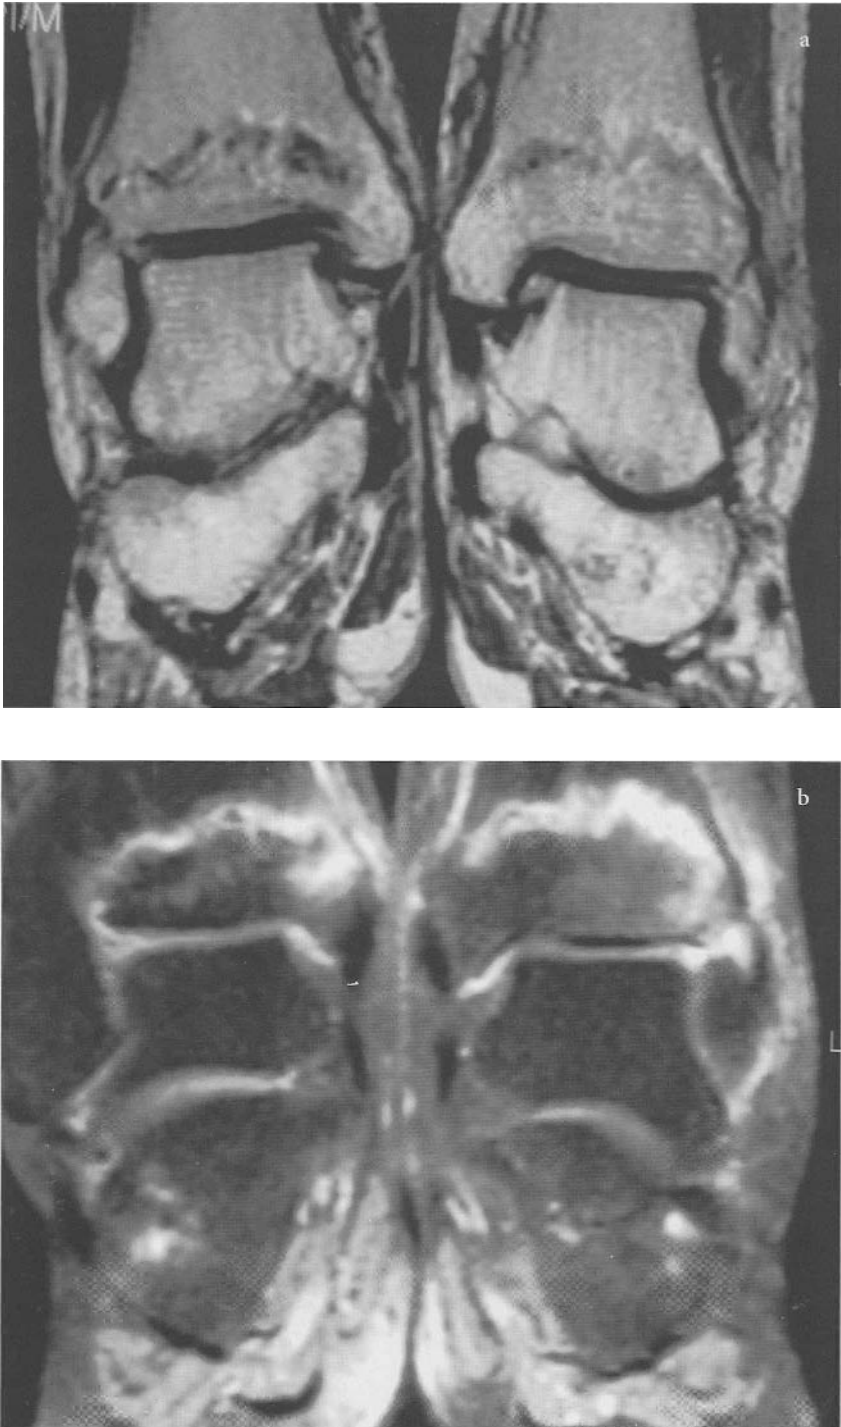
MRI: T1 (fig. a, left side). T1 fat-sat gadolinium (fig. b, right side). Talo-navicular arthritis, and strong enhancement after gadolinium injection.
